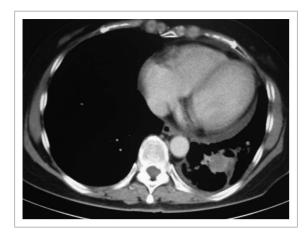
CT chest (month 3 from CIMAvax commencement), left lower lobe lesion 2 by 2.1 cm.
